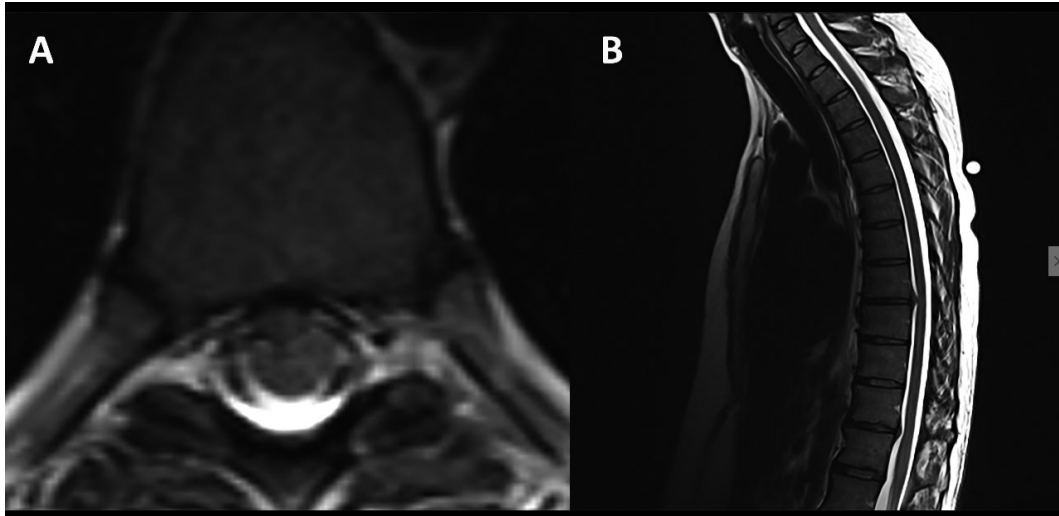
A. T2 axial MRI and B. T2 sagittal MRI of the thoracic spine demonstrates a right paracentral T8-T9 disc herniation with compression of the spinal cord. There is no evidence of spinal cord edema.
